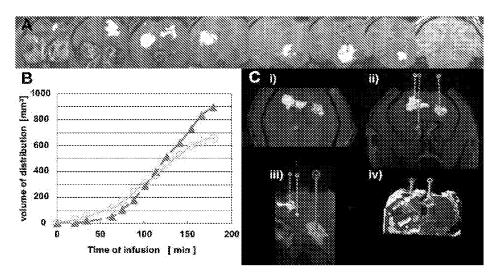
Serial coronal MR images with 5 mm interval obtained at the end of infusion (A; left, rostral; right, caudal). Total of 300 µl for each site was infused to corona radiata, putamen, and brain stem using CED. Volumes of distribution (mm<sup>3</sup>) were plotted against time elapsed (min) from the beginning of infusion (B; yellow, corona radiata; green, putamen; red, brain stem). Three-dimensional reconstruction of the acquired MR images after 300 µl CED infusion into each targeted sites (C; i, axial image; ii, coronal image; iii, sagittal image; iv, three dimensional reconstructed image). Lines depict the cannula tracts.
